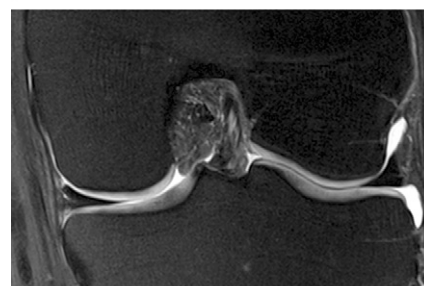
Extremity 1.0-T MR image. Coronal short tau inversion-recovery image (6650/15; inversion time, 100 msec) shows focal full-thickness cartilage defect at the lateral tibial plateau (arrows).
